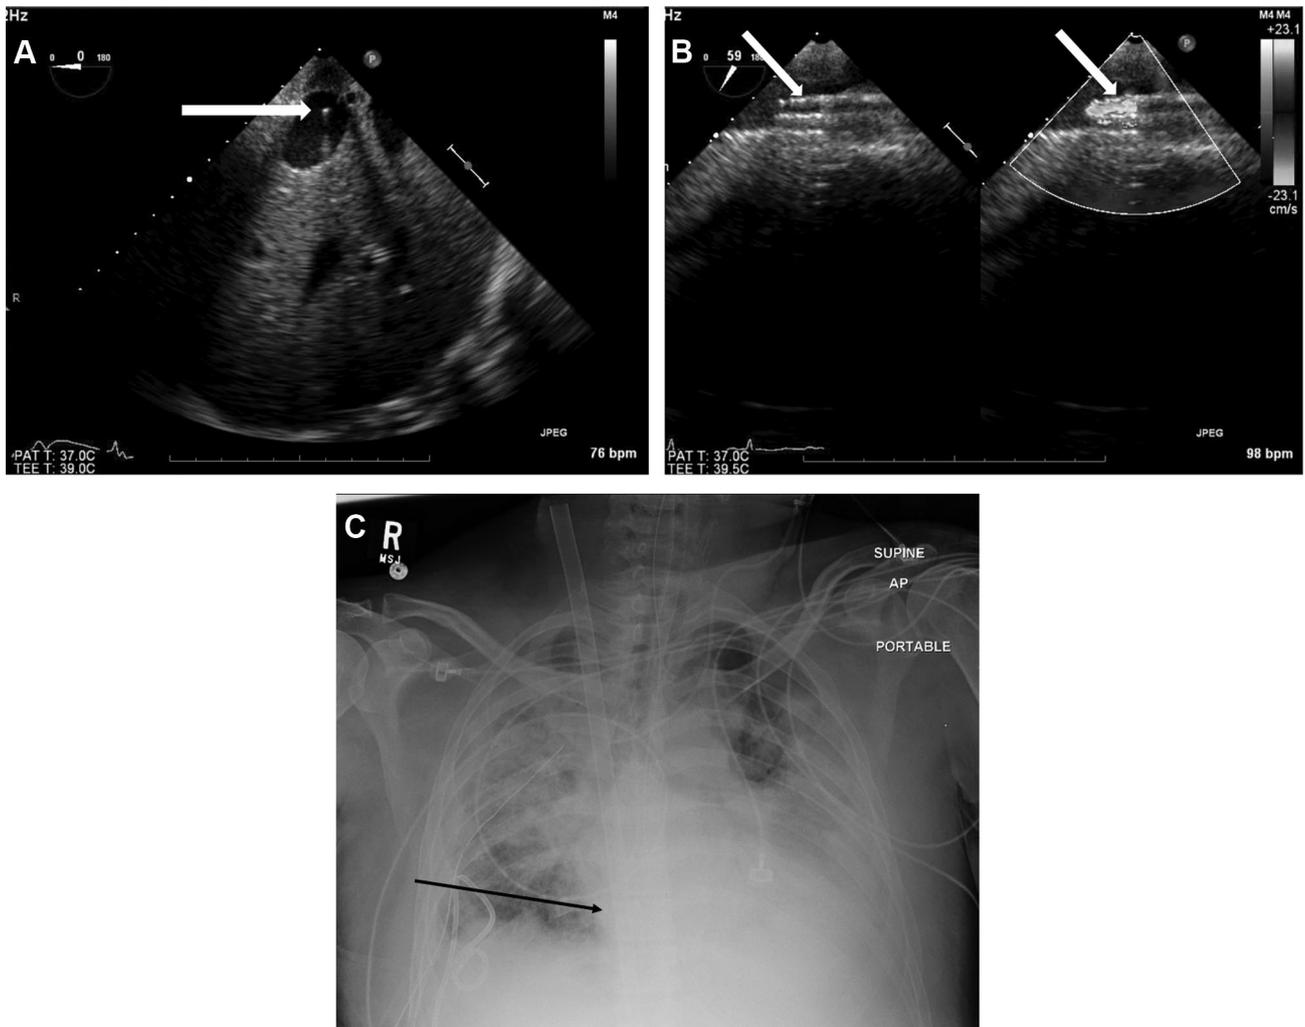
A–C: The wire or catheter tip in the IVC on TEE and CXR. IVC, inferior vena cava; TEE, transesophageal echocardiogram; CXR, chest x-ray.
